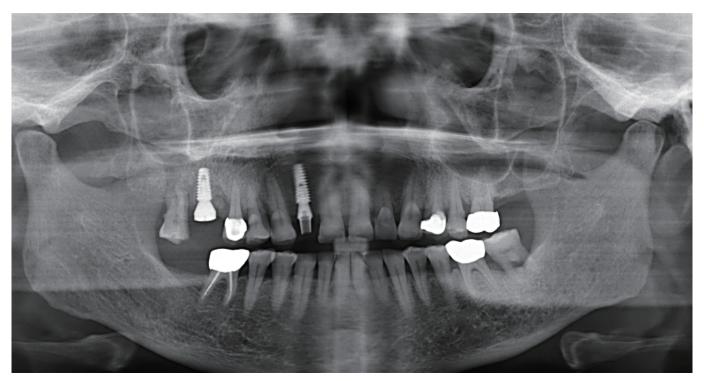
Pre-op panoramic x-ray..
